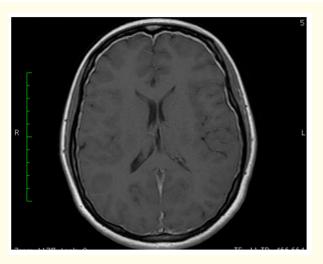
T1 axial MRI demonstrating gadolinium-enhanced in pachymeninge (white arrow).
